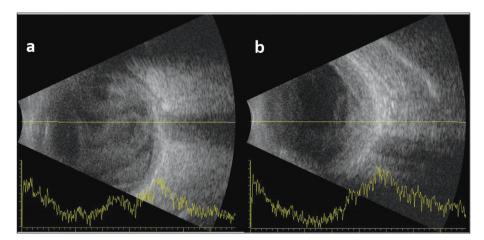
The B-scan ultrasonography of the globe. a) Initial ultrasonography. b) After treatment.
